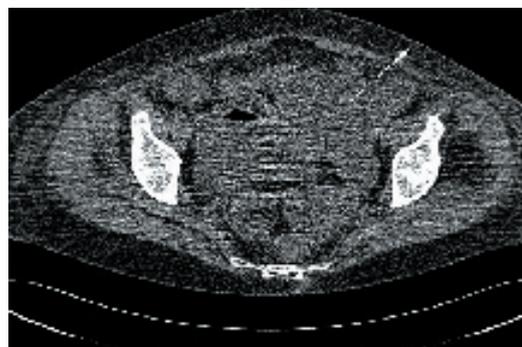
CT guided aspiration of abscess in the left iliac fossa
